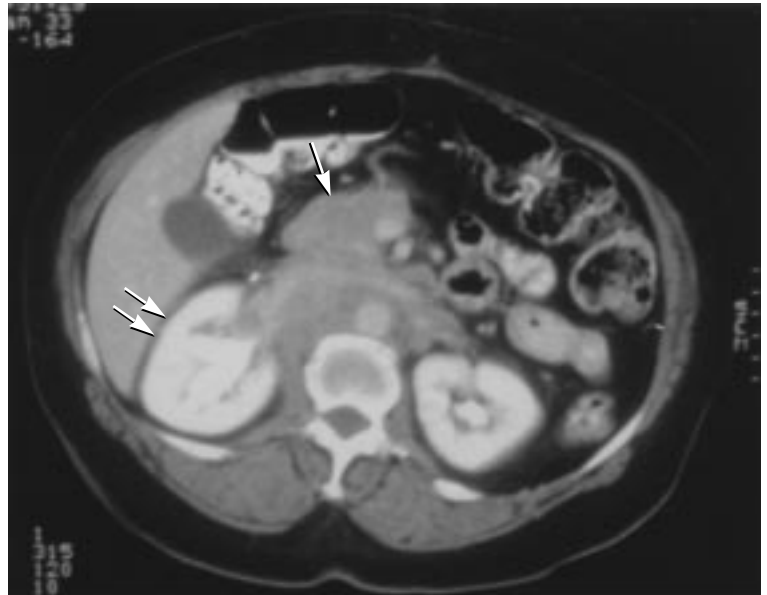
Abdominal computed tomography scan in June 1997 shows a large retroperitoneal soft tissue mass (arrow) and right hydronephrosis (double arrows)
